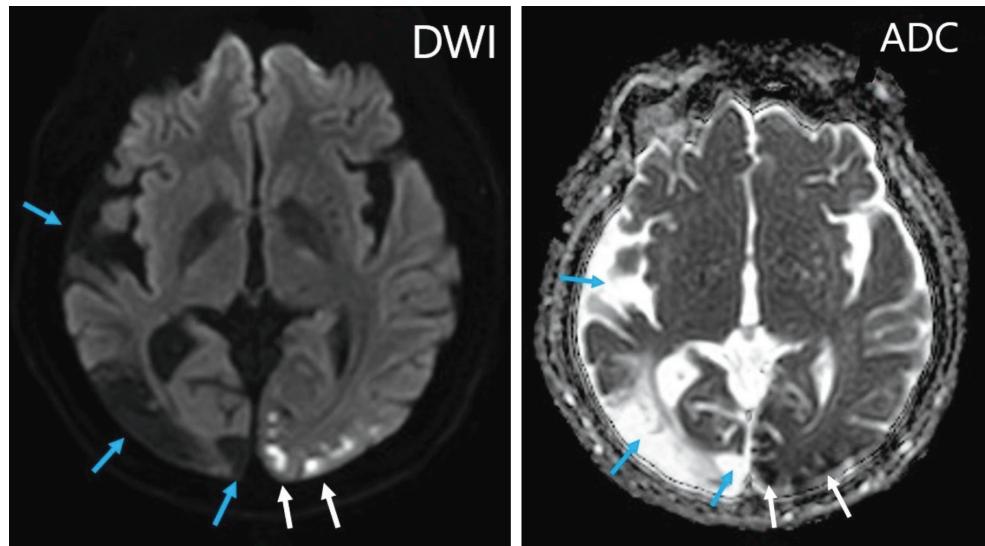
MRI (DWI and ADC): acute infarction at Lt occipital cortex (white arrow). Gliotic and encephalomalacia changed at right temporal lobe and right occipital lobe, representing old infarctions (blue arrow).
